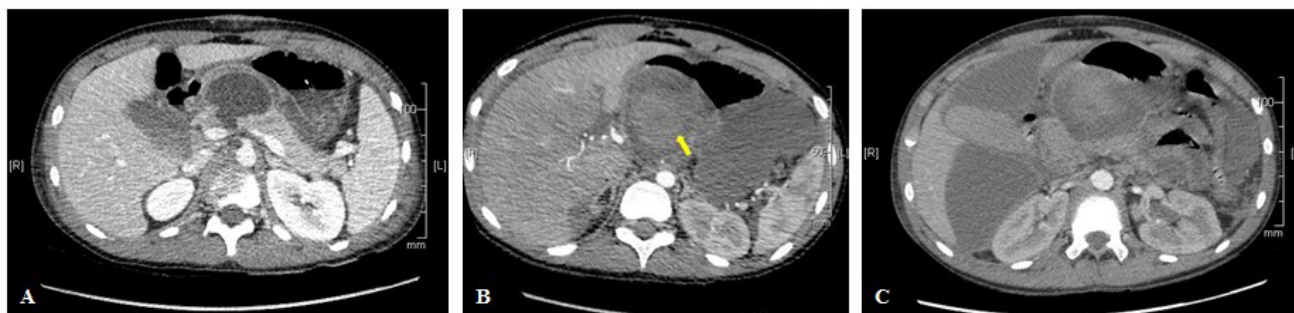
CT scan at day 14 showing uncomplicated pseudocyst and the pancreatic trauma.
